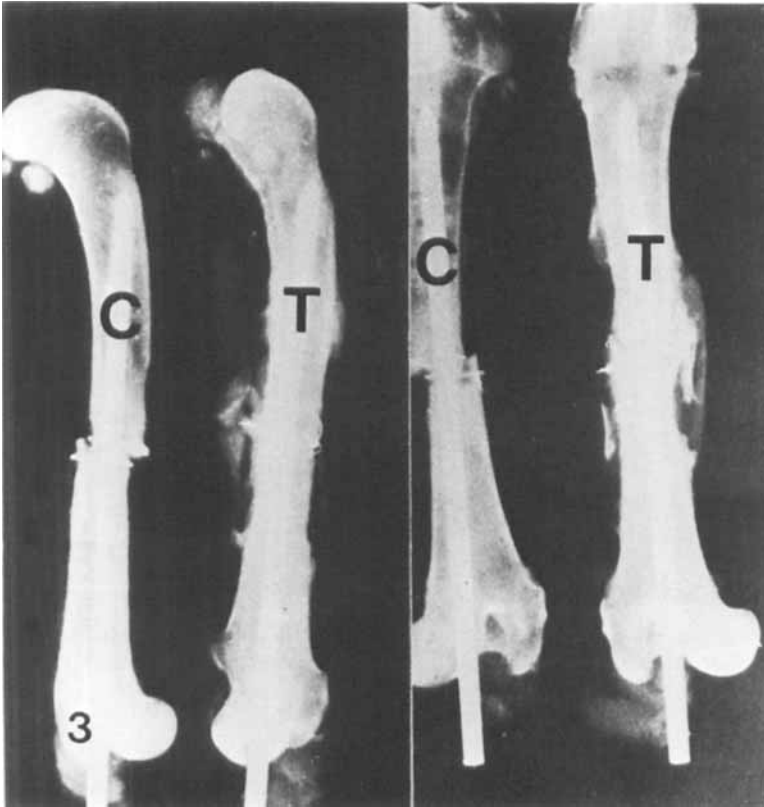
Radiographs of two different test femurs and their controls 10 months following surgery, revealing obvious differences between those areas that were supplemented with bone grafts and those lacking them. T - test femur; C - control.
